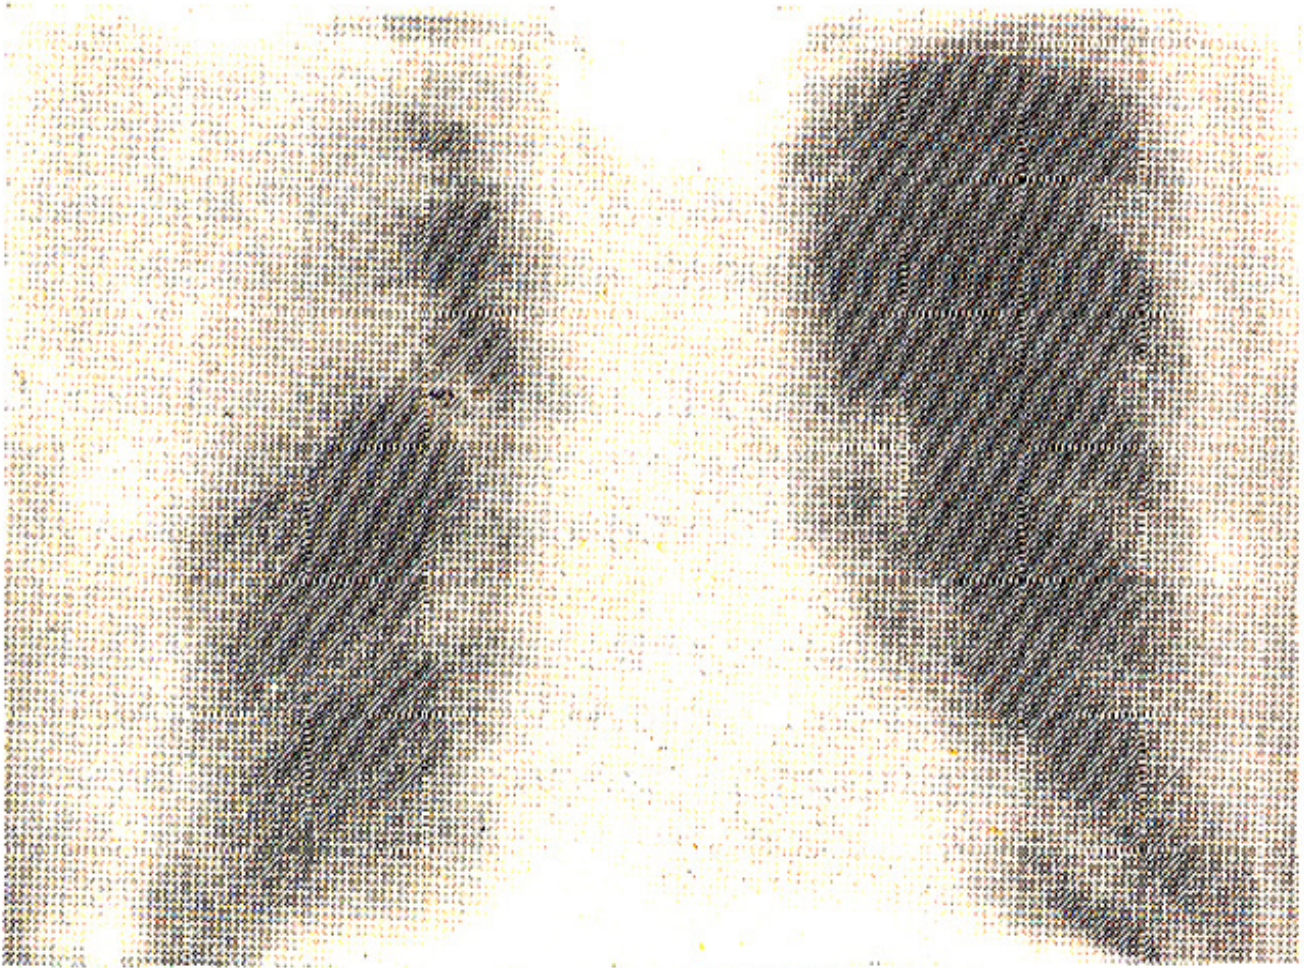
X-ray chest, showing a well demarcated opacity in the upper and mid zone of the right lung.
